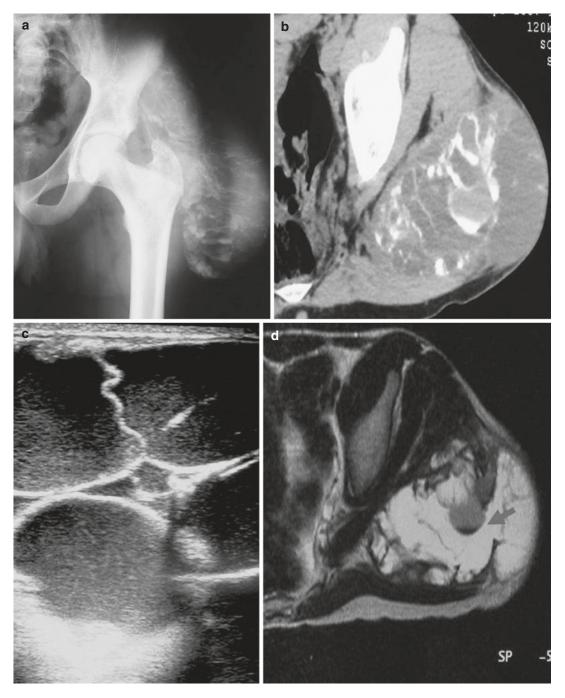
Tumoral calcinosis in a 12-year-old boy. (a) Anteroposterior radiograph of the left hip shows a well-demarcated lobulated calcified mass with fluid-calcium levels also known as the "sedimentation sign." (b) CT image of the left hip: the mass shows a mainly cystic component with low-attenuation centers and thin calcified walls. Fluid-calcium levels are noted. (c) Ultrasound study shows multicystic mass. Cysts contain hypoechoic liquid and are separated by hyperechoic thin septa. (d) Axial T2-weighted MR image shows a well-circumscribed multicystic mass with heterogeneous and high signal intensity (*arrow*)
